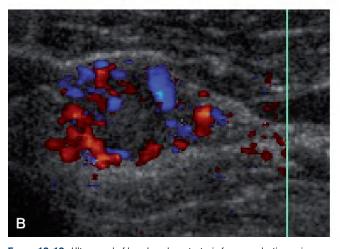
Ultrasound of lymph node metastasis from anaplastic carcinoma: right segment 4. A, Transverse diameter: 13 mm. B, Color Doppler, Transverse.
